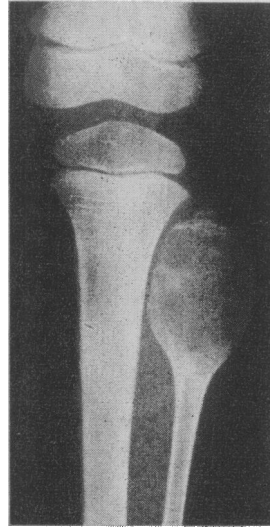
(*Case I*).—Radiograph showing the expanded upper end of the fibula, the irregular line of dense bone adjacent to the epiphyseal plate and the small, rarefied ossific centre of the epiphysis.
